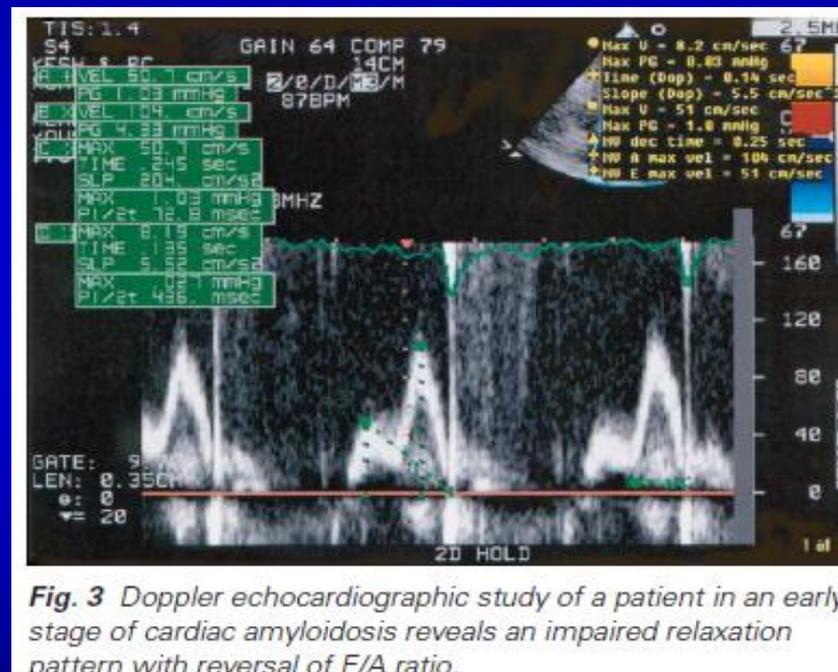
Doppler echocardiographic study of a patient in an early stage of cardiac amyloidosis reveals an impaired relaxation pattern with reversal of E/A ratio.
